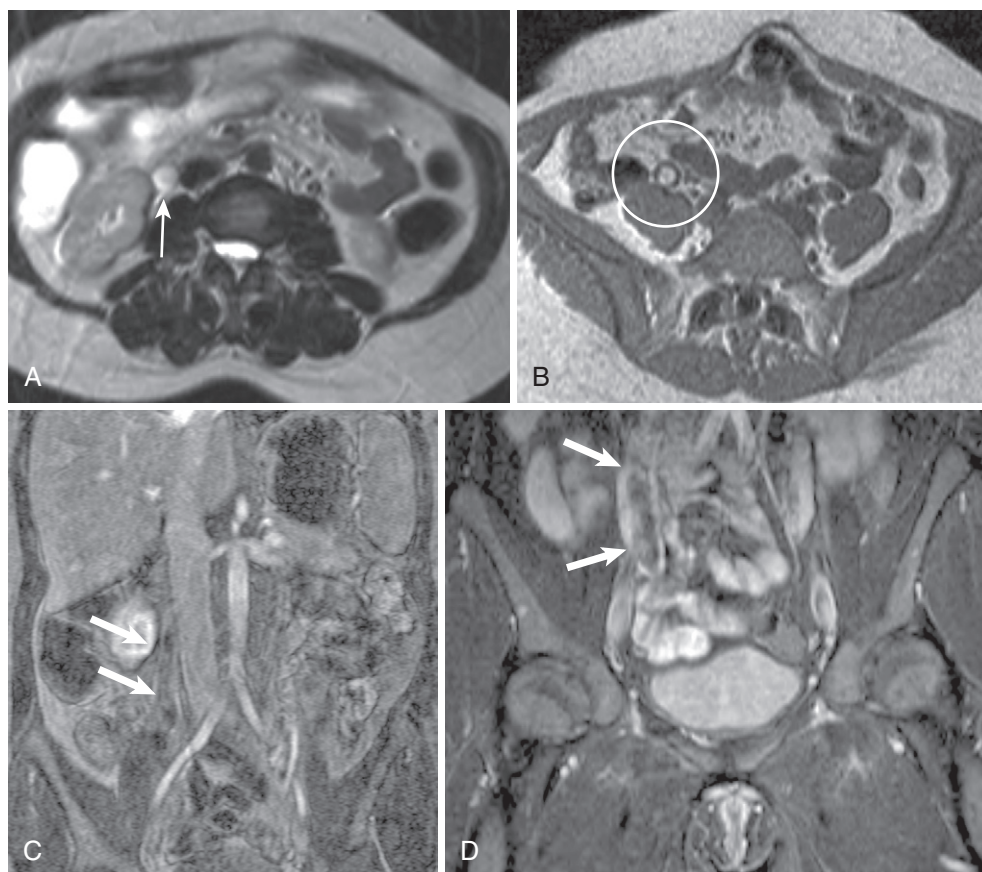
Ovarian vein thrombosis. A, A circular hyperintensity (*arrow*) corresponding to the distal ovarian vein abuts the inferior vena cava near the right kidney on the T2-weighted image. B, Corresponding hyperintensity on the in-phase T1-weighted gradient echo image indicates acute clot (*circle*). C and D, Coronal images from a gadolinium-enhanced three-dimensional magnetic resonance venography (MRV) display filling defect (*arrows*) within the upper (C) and lower (D) ovarian vein.
